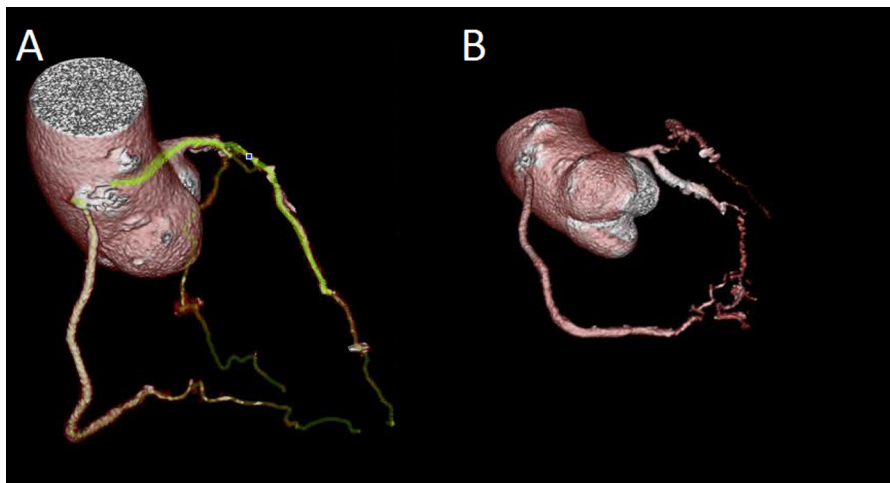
3D CT reconstruction showing the course of the occluded LAD in AP cranial (A) and LAO caudal (B) views.
